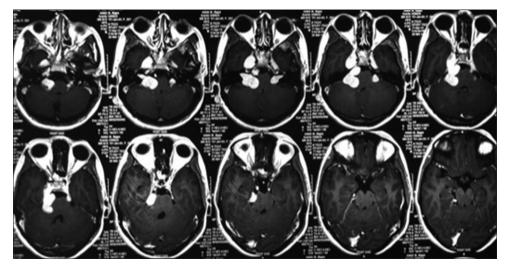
Postcontrast magnetic resonance imaging images axial sections showing various schwannomas
